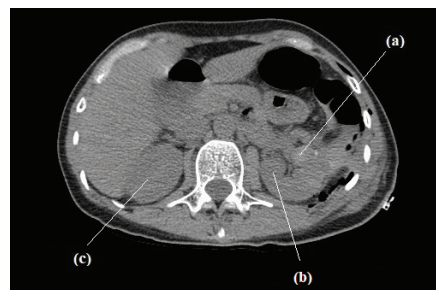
Computed tomogram on the 6th day after surgery
